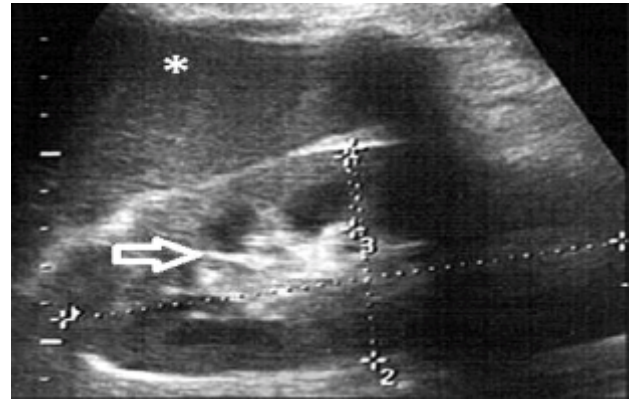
Abdominal section ultrasound reveals Grade 1 renal cortical echogenicity, meaning the right kidney's cortico-medullary definition (arrow) is preserved, and the kidney's echogenicity is the same as that of the liver (star).
